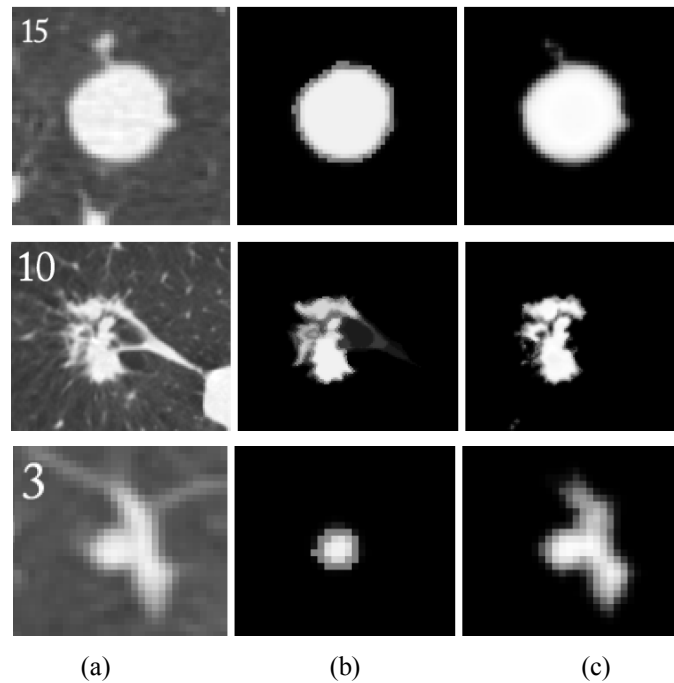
(a) CT data, axial or coronal sections zoomed in on the nodule with a lung window level, W/L = 1400/-600 HU (b) Truth (c) Segmented lung regions [31]
